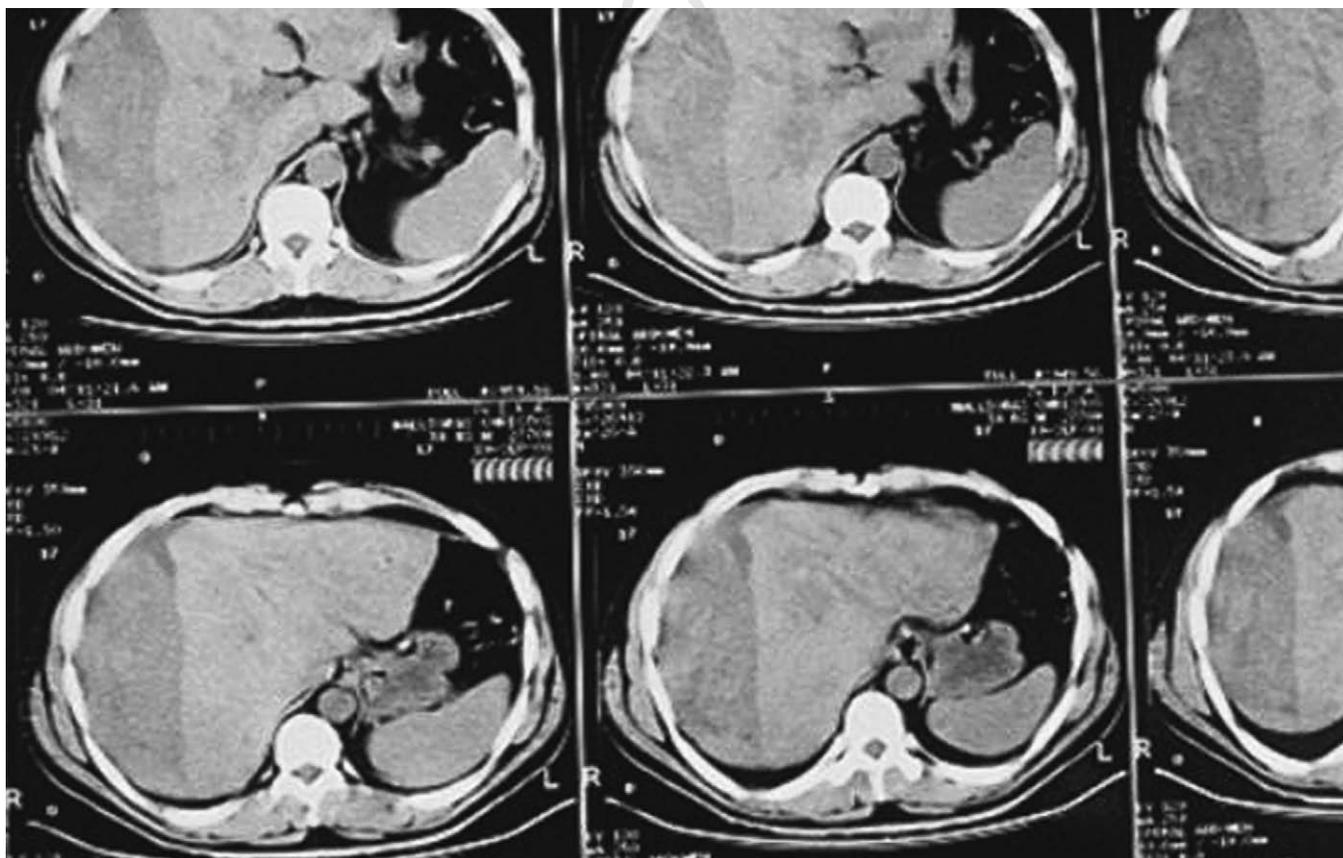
Patient with a cavernous haemangioma of the liver. Computed tomography scan after admission showing a giant haemangioma on the right lobe of the liver.
